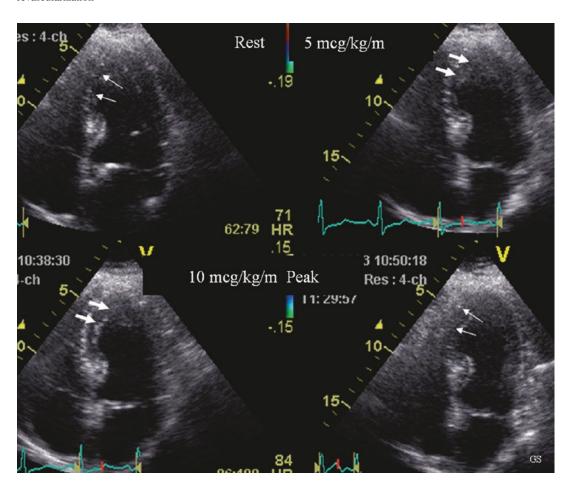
Detection of myocardial viability with dobutamine stress echocardiography. The resting image shows an apical septal wall motion abnormality, which improves at 5 and 10 mcg/kg/min of dobutamine and deteriorates at
